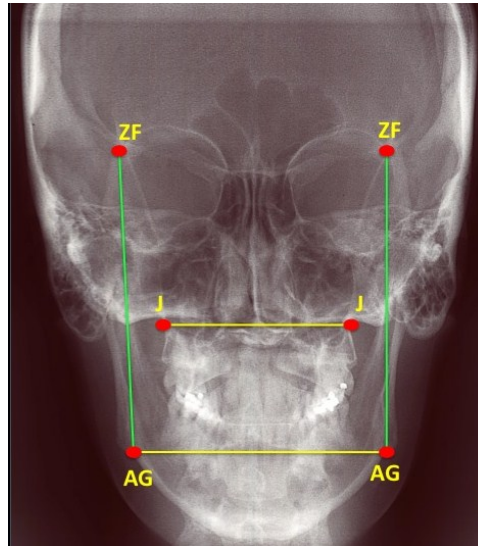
Anteroposterior Cephalometric Radiograph
